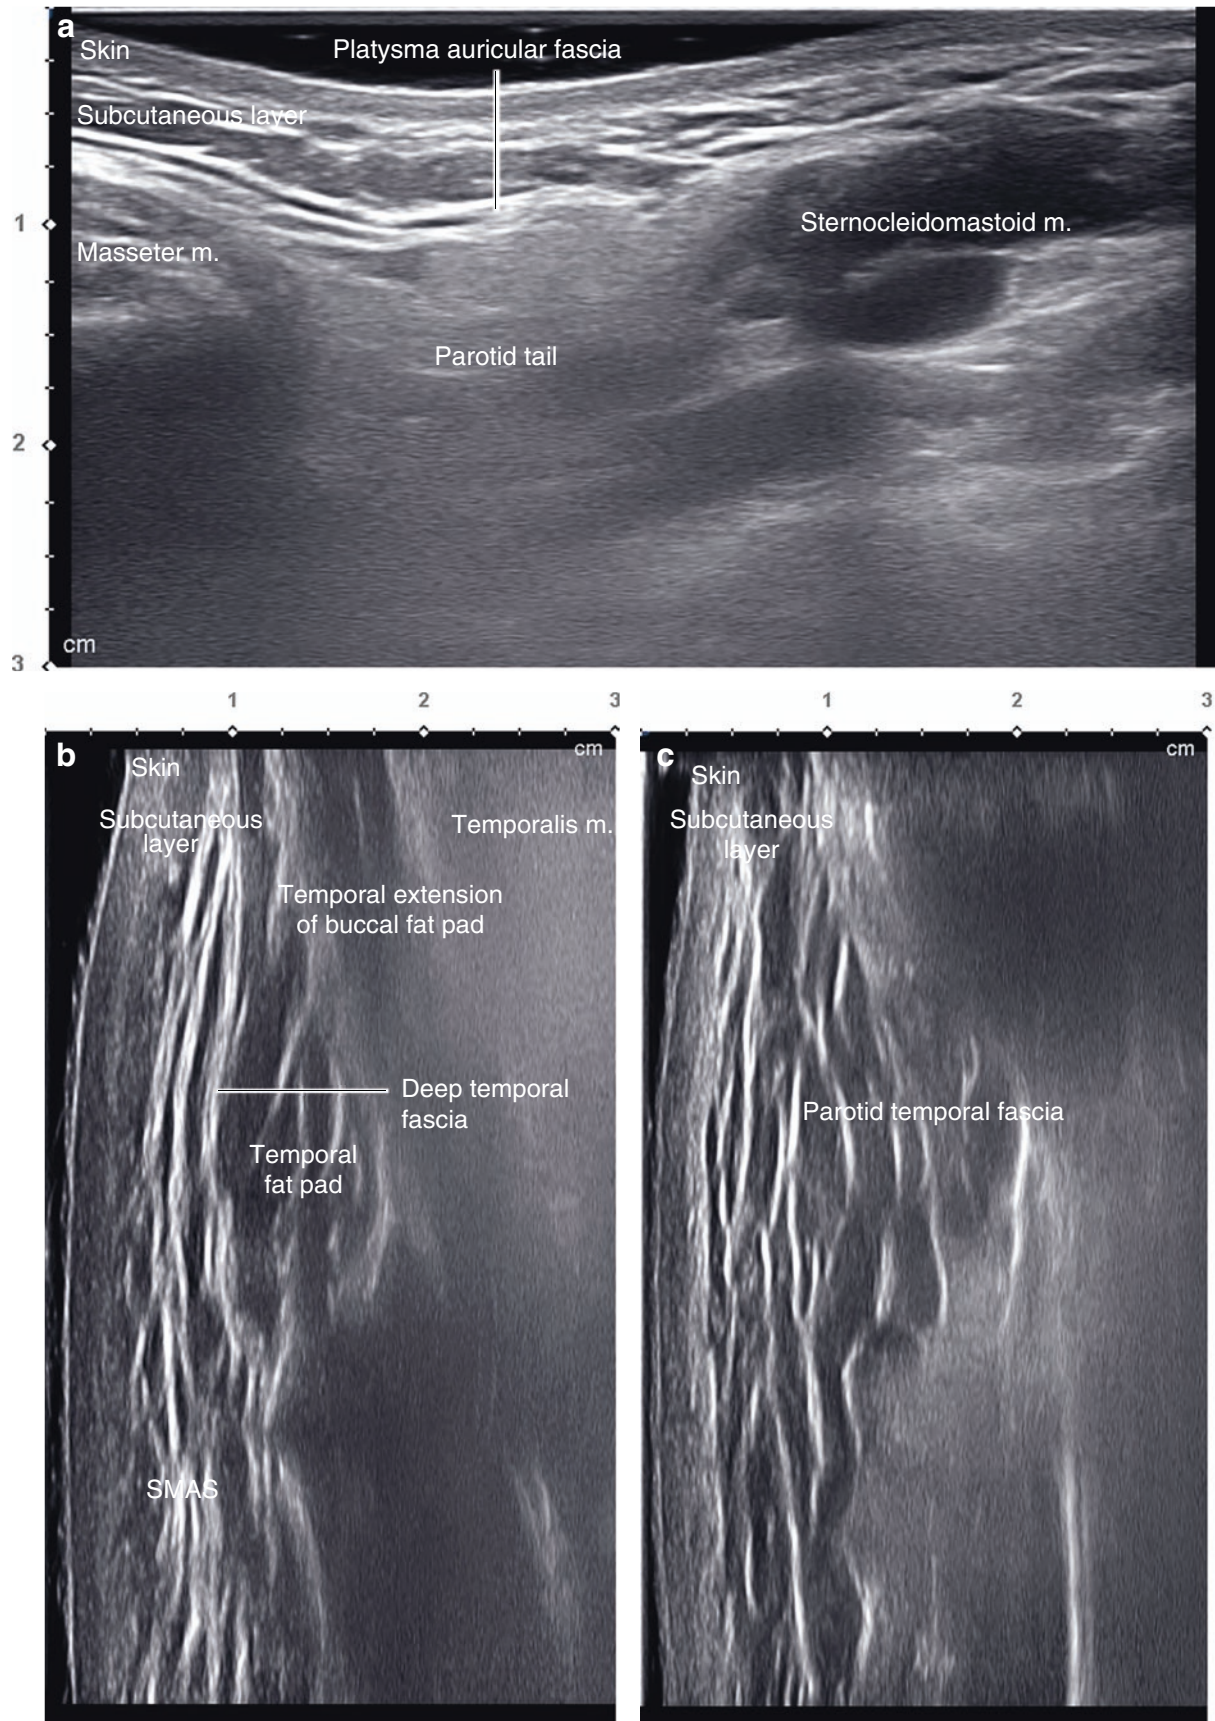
Ultrasonography of anchoring points for lifting thread. (a) Platysma auricular fascia, B mode (transverse view, 15 MHz by linear transducer), (b) deep temporal fascia, B mode (coronal view, 15 MHz
